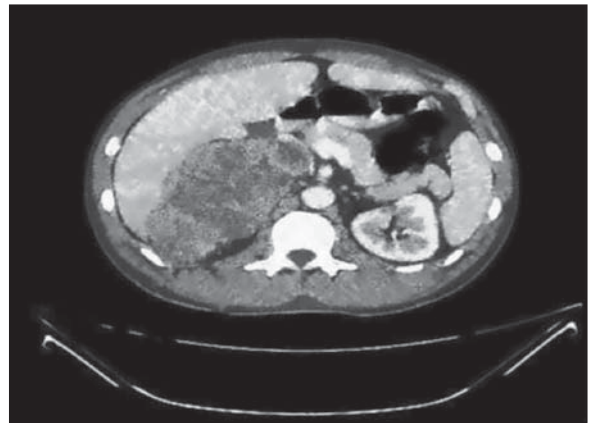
The appearance of the giant adrenal mass on CT.
